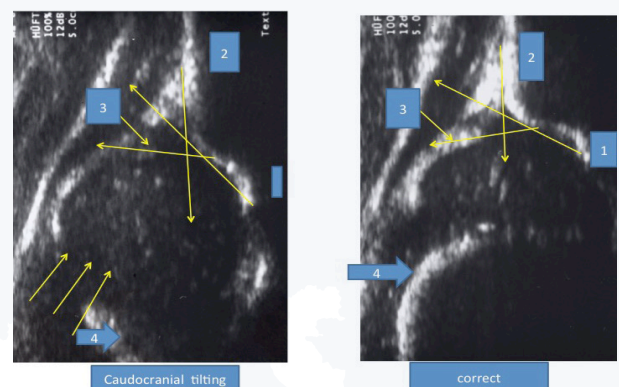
Left: incorrect sonogram with caudocranial tilting effect, which leads to overdiagnosis. Compare with the right sonogram from the same joint. 1 lower limb of os ilium. 2 plane. 3 labrum. 4 chondroosseous border which is disappearing as a sign of tilting in the left sonogram. Arrows shoe the direction of the ultrasound beams. Compare Alpha/ Beta in the same joint! Deacreasing Alpha and increasing Beta because of tilting (or sector probes) only!
